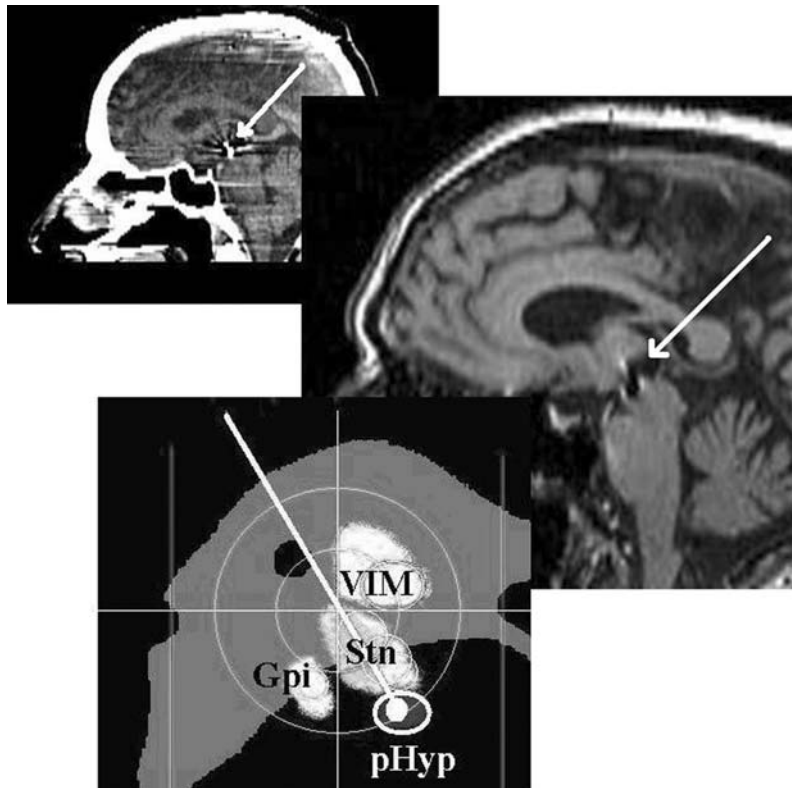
Sagittal CT and MRI slices showing the active contact of the electrode stimulating the posteromedial hypothalamus (*white arrows*). The inferior box shows the target on the ventriculogram registered to the bicommissural system
